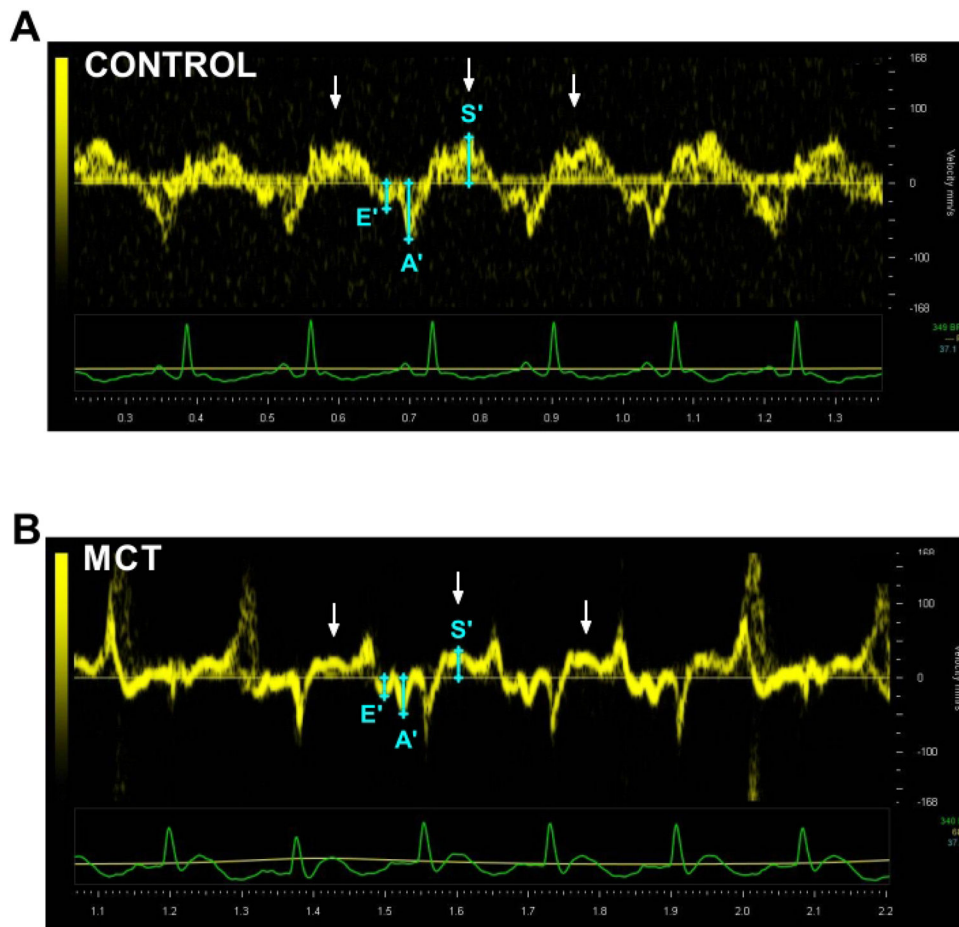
Tissue Doppler of the lateral tricuspid annulus.
